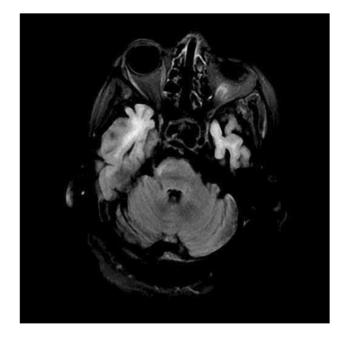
Two months after receiving treatment, the previously described T2/FLAIR hyperintensity in the cerebellum is no longer visualized. It is also showing a stable anterior temporal lobe hyper-intensities
